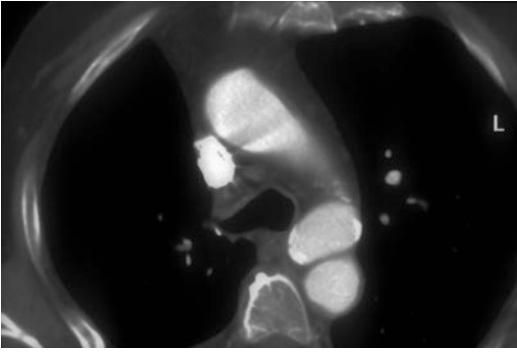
Axial CT in a patient with chronic posttraumatic pseudoaneurysm of the aortic isthmus. There is no mediastinal hematoma and there are some calcifications along the aneurysmal wall
